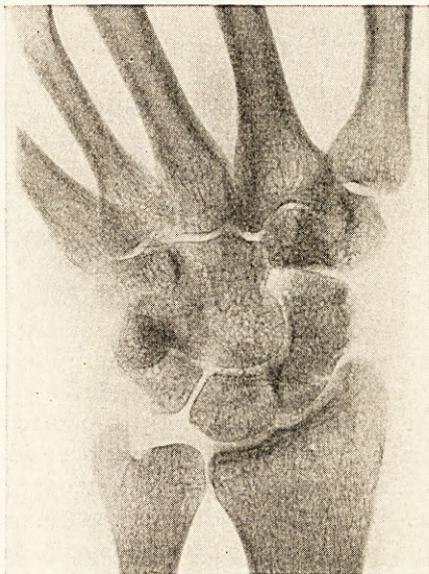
X-ray of wrist, showing atrophy of disuse. Taken after four months' immobilisation in plaster for ununited fracture of the navicular.
